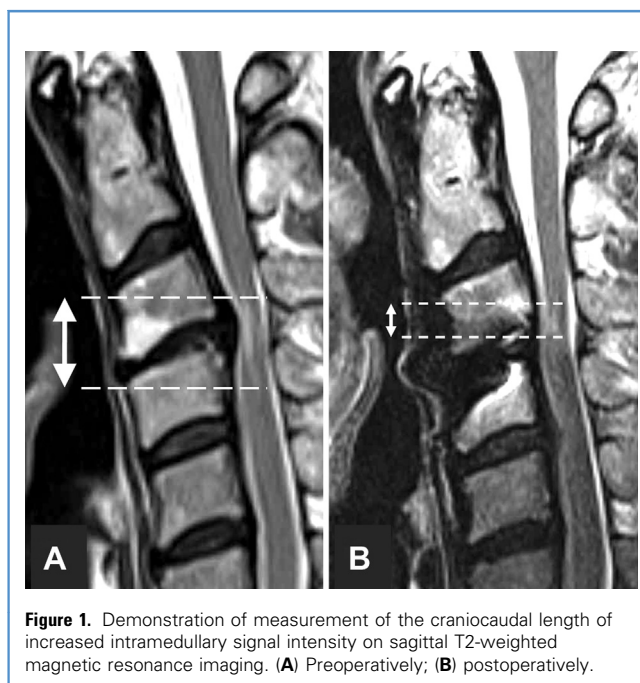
Demonstration of measurement of the cranio-caudal length of increased intramedullary signal intensity on sagittal T2-weighted magnetic resonance imaging. (A) Preoperatively; (B) postoperatively.
